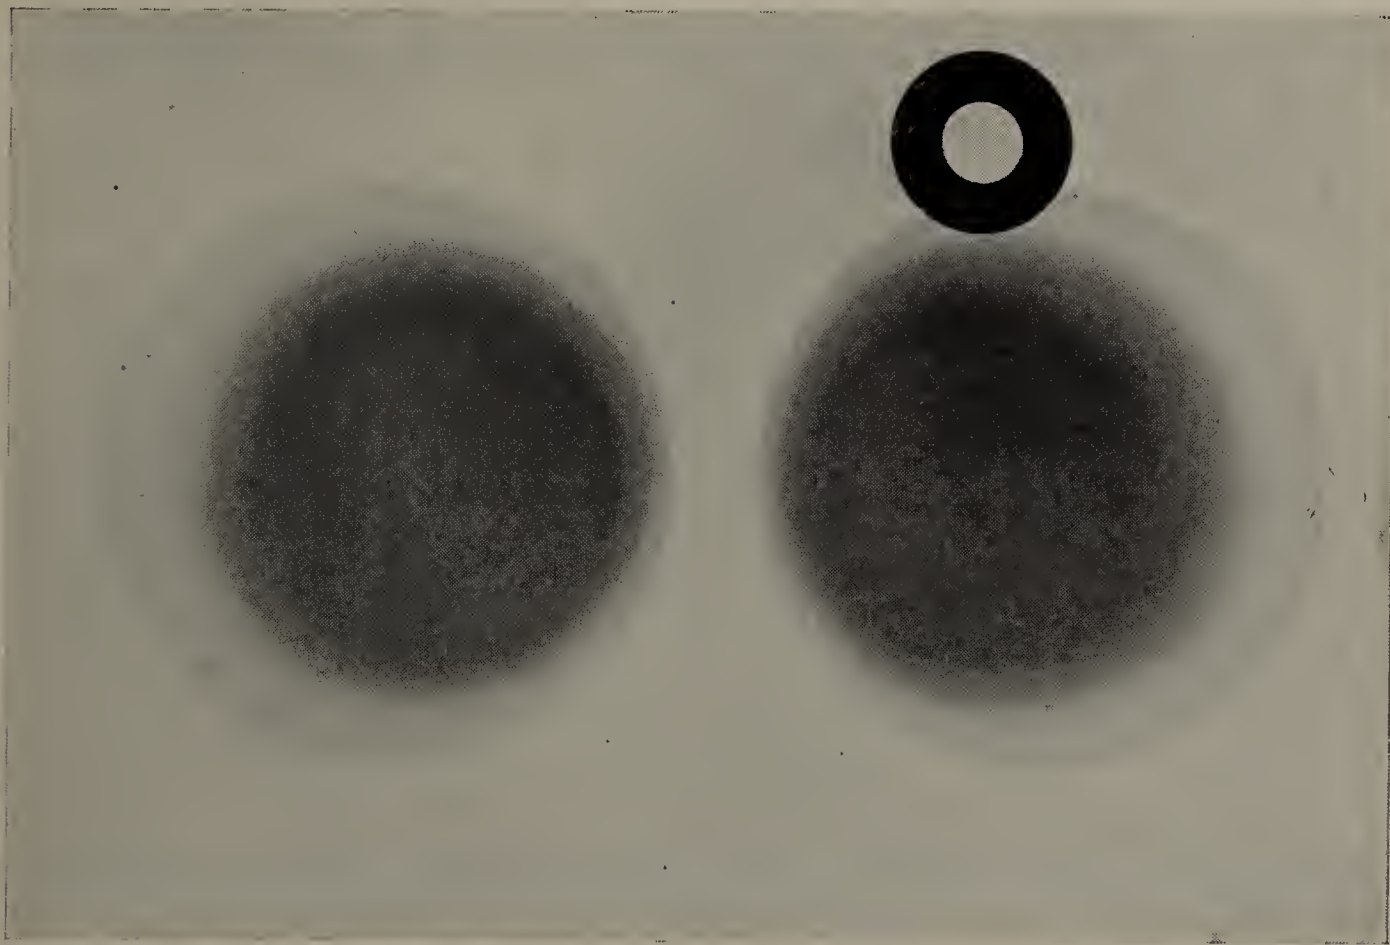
Cut made from a radiograph of two similar vulcanite cups. The one containing water, the other blood, in equal amounts; the cup holding the blood has a metal ring beside it.
